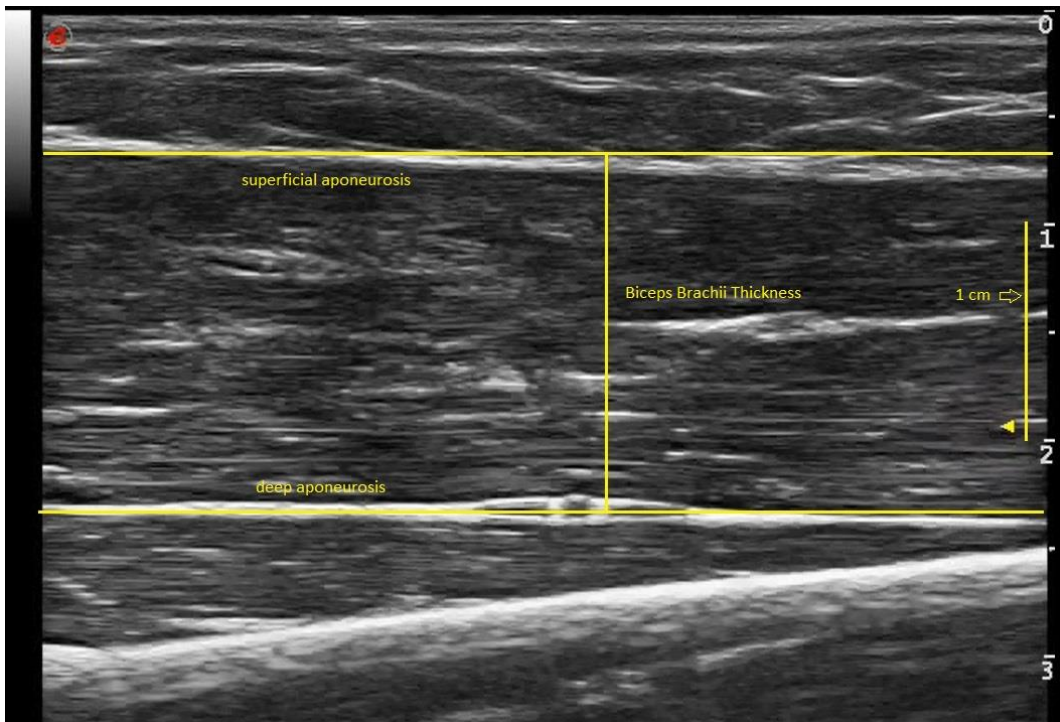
Sagittal plane ultrasound at 60% length of the humerus showing biceps brachii from a participant of the work described in the current thesis.
